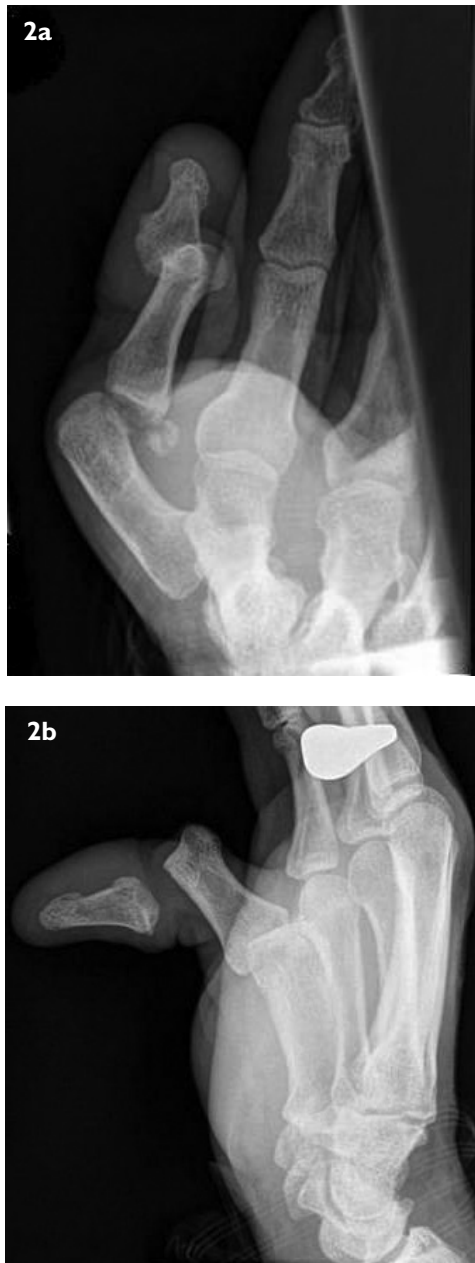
Anteroposterior and lateral radiographs show the characteristic injury pattern, with volar and dorsal dislocations of the (a) metacarpophalangeal joint, and (b) interphalangeal joint.
